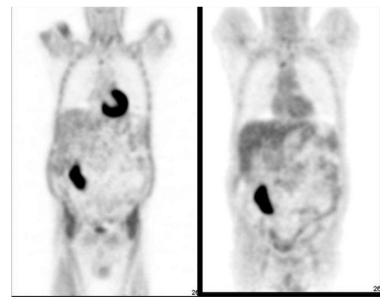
Fasting prior to study will alter the FDG biodistribution. Left: Image acquired after FDG was administered in the hyperglycaemic state, showing increased radiotracer uptake in muscles (especially in the thorax and pelvis) and reduced uptake in the liver. Right: Image acquired after fasting, showing reduced FDG uptake in the muscles and increased uptake in the liver.
